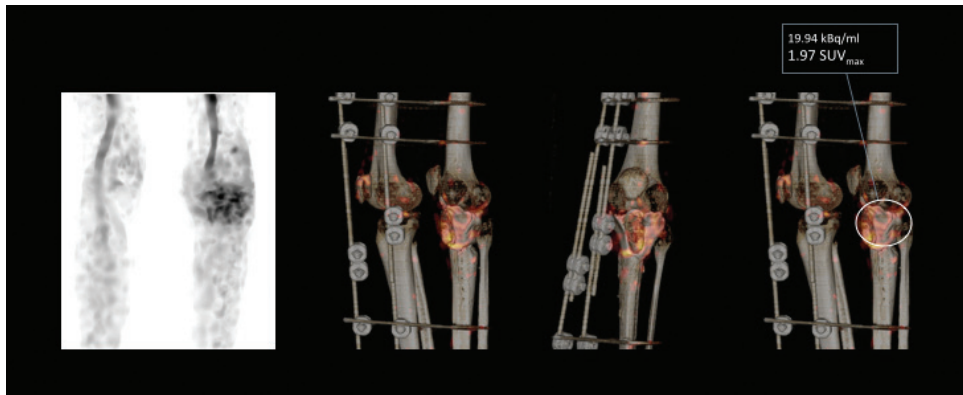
Post-surgery follow-up SPECT/CT infection imaging with ^{99m}Tc antigranulocyte antibodies with SUV quantification using xSPECT Quant.
